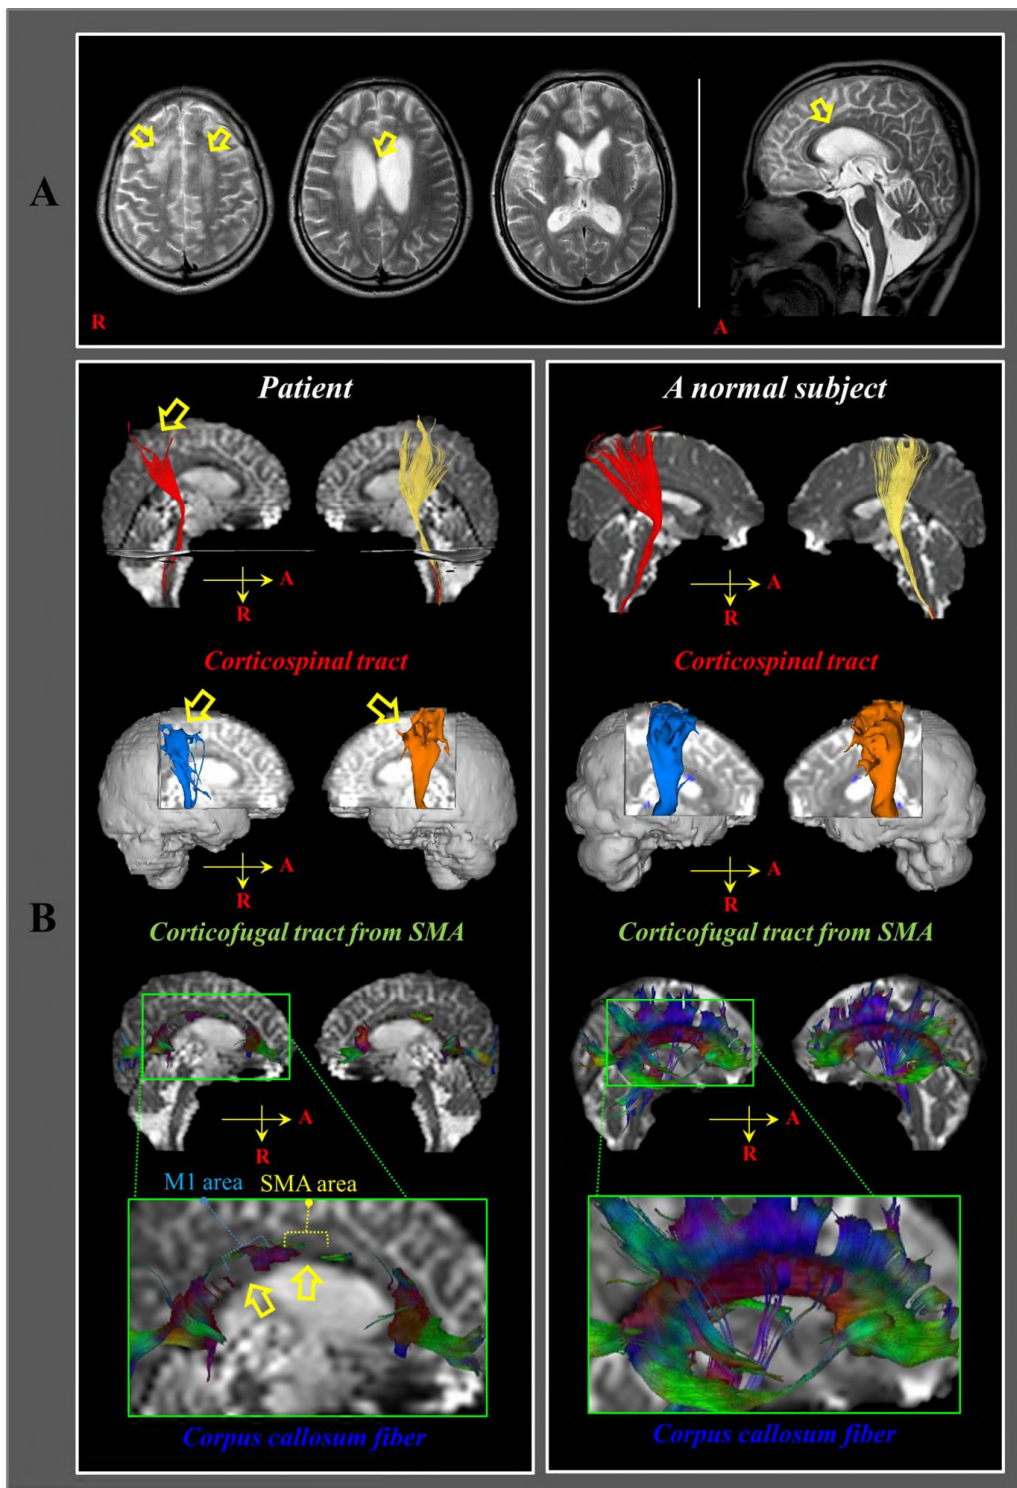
(A) T2-weighted magnetic resonance images at 16 months after onset show leukomalactic lesions in both prefrontal lobes and the subcortical white matter (arrows) and in the thinned body of corpus callosum (arrow). (B) On 16-month diffusion tensor tractography, a partial tearing at the subcortical white matter (arrow) is observed in the right corticospinal tract. The corticofugal tracts from the secondary motor area (SMA) show narrowing (right) and partial tearing (both, arrows) compared to that in a normal subject (35-year-old male). Injuries of the corpus callosum fibers from the primary motor cortex (M1) and the SMA in both hemispheres are also present (arrow).
